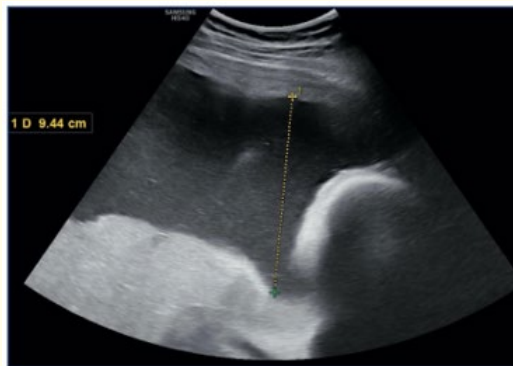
Prenatal ultrasonography in an axial section of the large cistern, showing an abundance of amniotic fluid. The anteroposterior diameter of the large cistern measures 9.44 cm.
